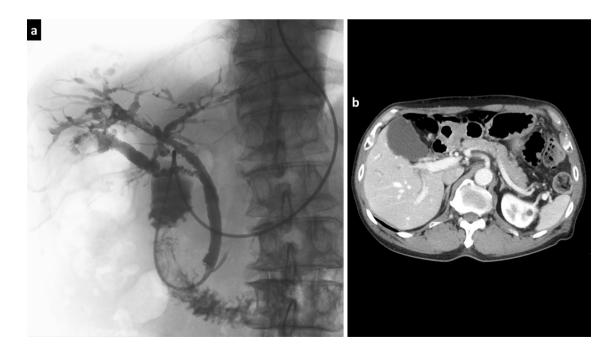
a Improvement of bile duct stricture is observed on a cholangiogram after 2 weeks of steroid therapy. b Contrast-enhanced computed tomography performed 6 months after the start of steroid therapy showing no pancreatic enlargement or atrophy
